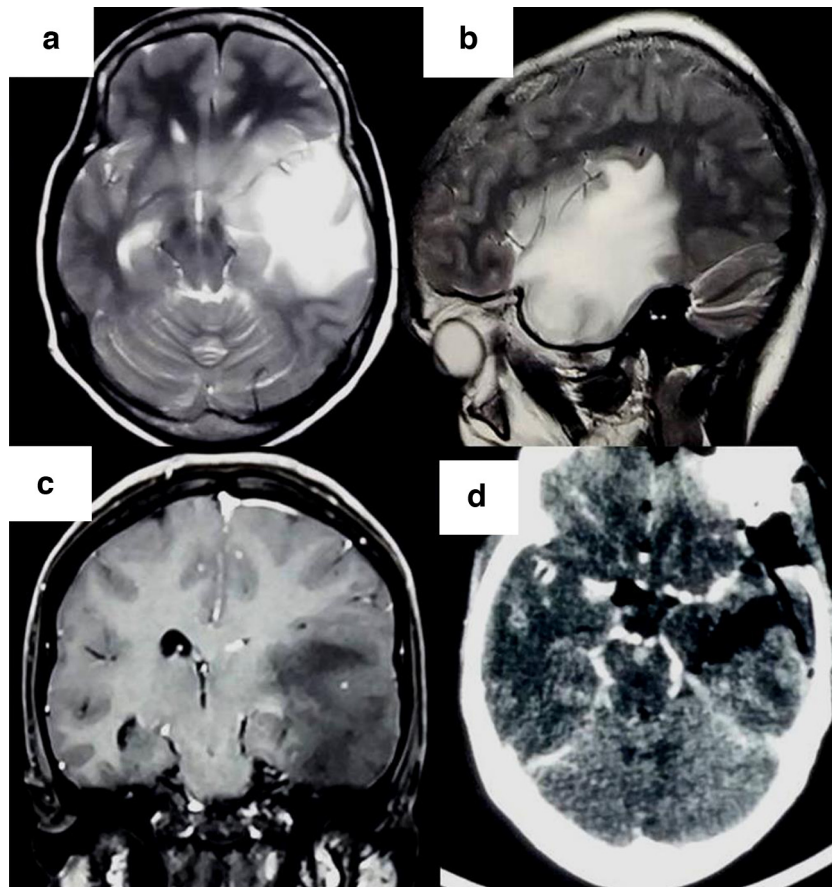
T2 weighted MRI of the brain a hyperintense mass occupying the left temporal lobe, extending from the temporal pole till the plane of the collicular plates (1a). The entire lateral temporal lobe is replaced by tumor right from the sylvian fissure till the temporal base (1b). The medial temporal lobe appears normal although there is evidence of midbrain compression by it (1a). The mass is non-enhancing on T1 contrast (coronal) image (1c). The compression of the ipsilateral lateral ventricle including the temporal horn is well seen on coronal image (1c). Postoperative scan shows surgical cavity with evidence of craniotomy (1d).
